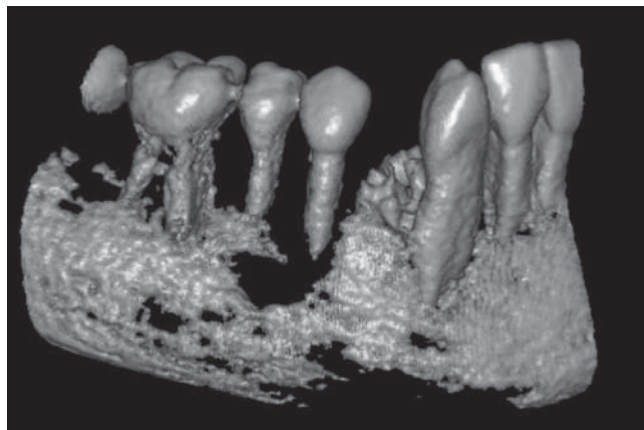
CBCT scan (patient J.B.).
